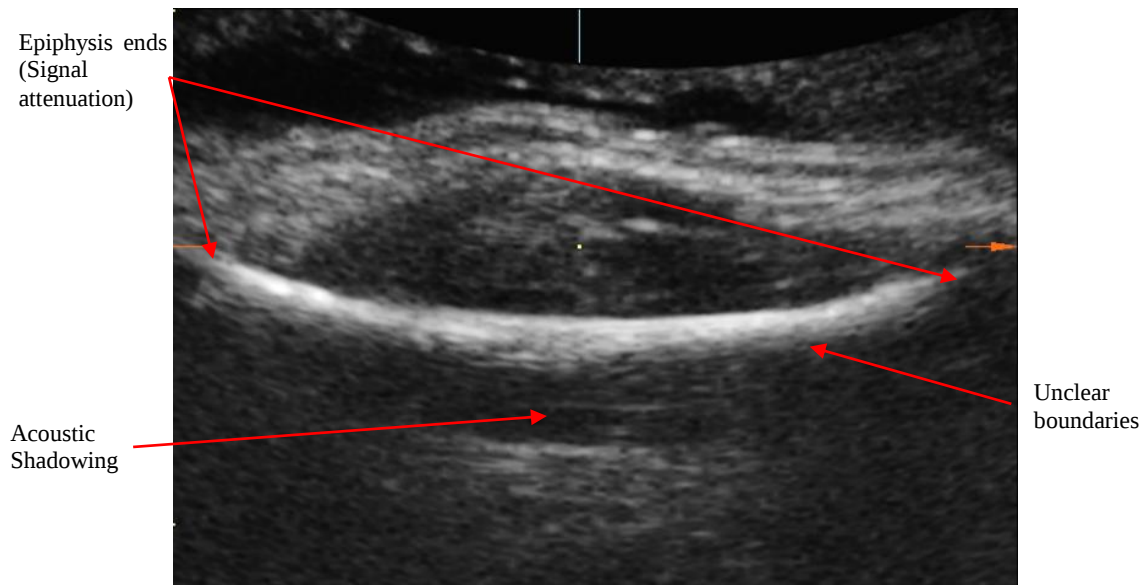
Ultrasound image of the fetal femur. The femur is represented by the white linear segment within the thigh tissues. The figure shows a few problems like poor anatomical definition, shadowing from the bottom part of the femur, loss of signal at the two epiphysis ends and low signal to noise ratio (Mahon, 2007).
